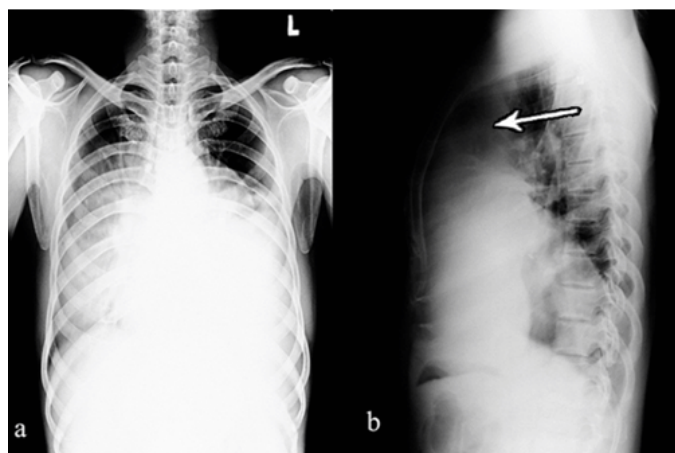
(a) Posteroanterior radiograph of chest showing large ill defined opacity involving mediastinum, extending into hemithorax on both sides, (b) Lateral radiograph of chest showing radiodense opacity filling the retrosternal space (arrow).
